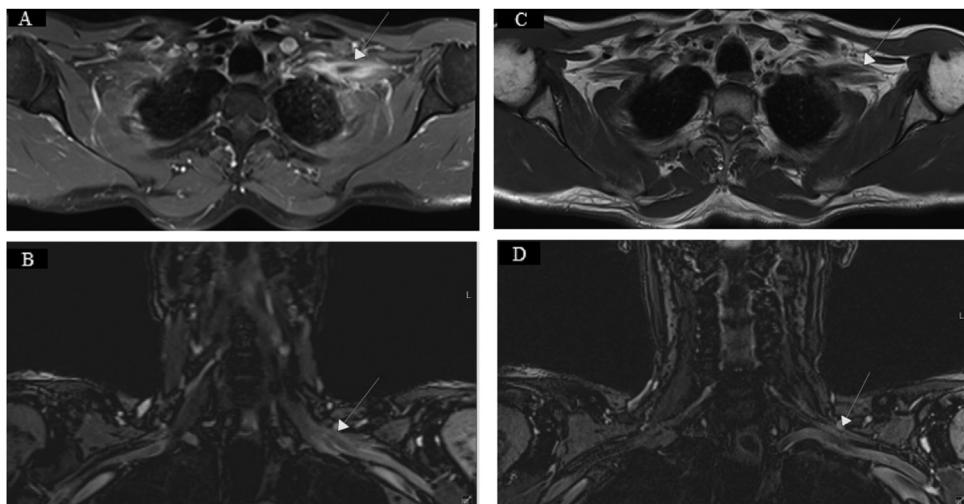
(A & B) Pre-HBO therapy axial and coronal MRI of the left brachial plexus. MRI reveals abnormal ill-defined enhancement surrounding the left brachial plexus at the level of the proximal and mid-left clavicle. (C & D) Post-HBO therapy axial and coronal MRI of the left brachial plexus revealing treatment response with significantly decreased abnormal enhancement compared to prior pre-treatment MRI.
